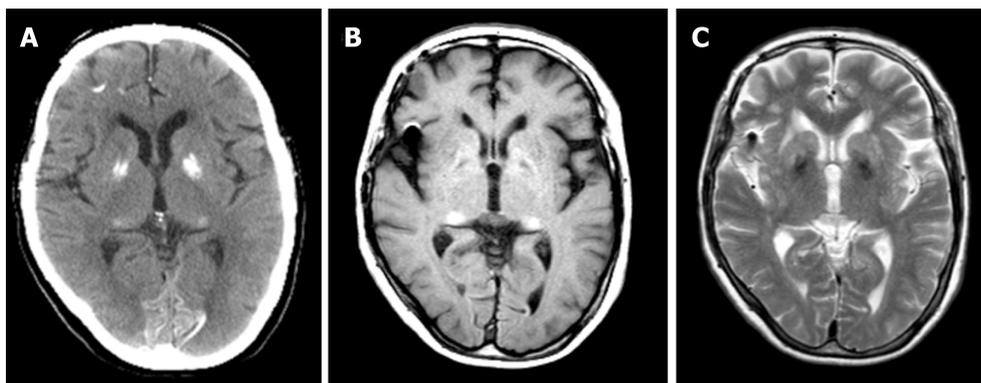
Computed tomography, magnetic resonance imaging-T1, and magnetic resonance imaging-T2 images of the proband (65 yr).
